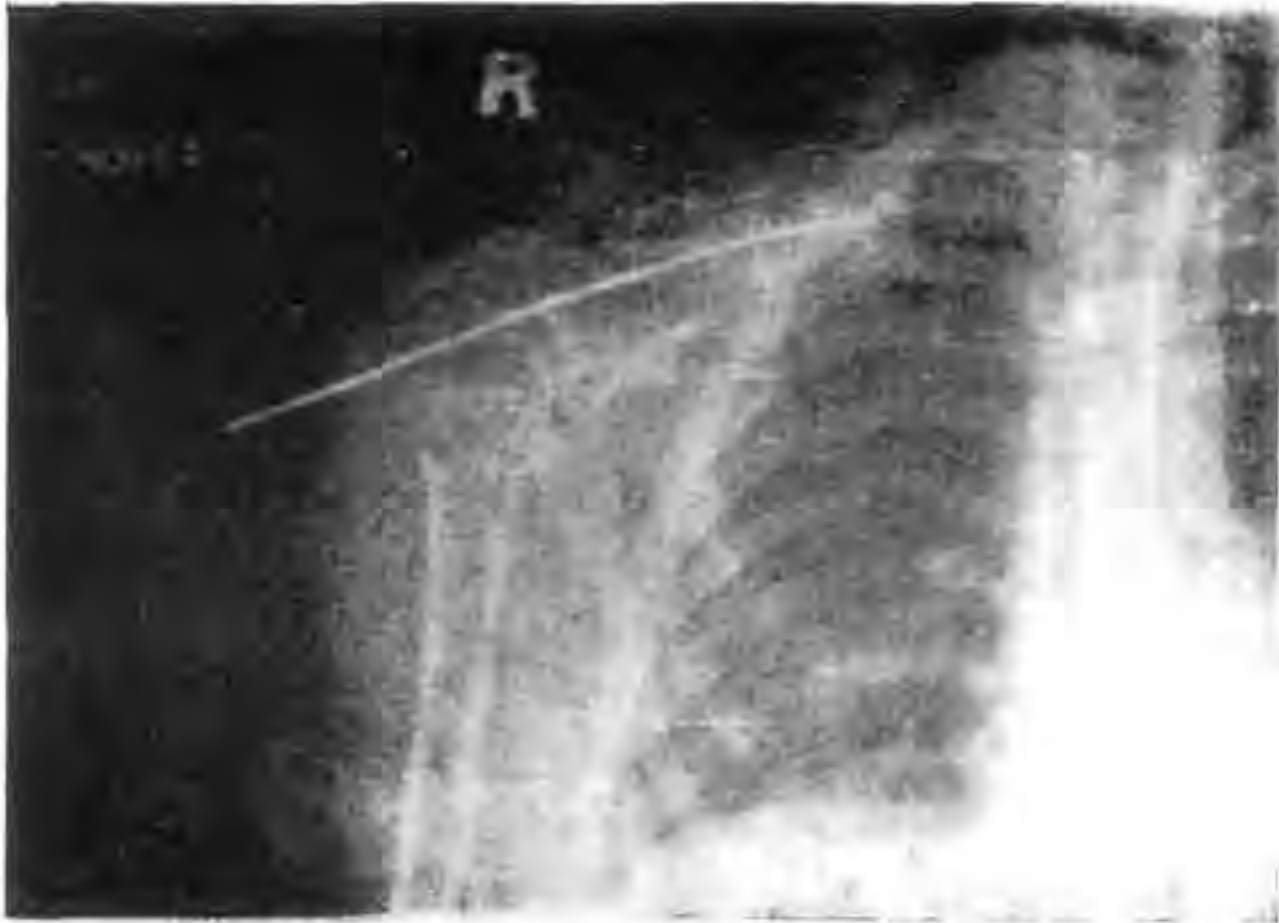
Immediate postoperative radiograph.
